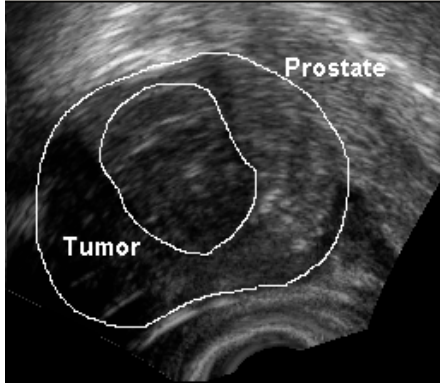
Prostate cancer in an ultrasound image
